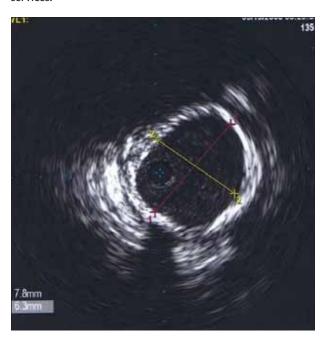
Intravascular ultrasound (IVUS) allows for accurate sizing and minimization of contrast. In this above image, the access arteries (iliacs) are measured and noted to be suitable for the introduction of a 20-F device. This allows for the entire abdominal or thoracic aortic endovascular repair (EVAR or TEVAR) to be performed without contrast and with minimal radiation exposure to the patient and staff.
